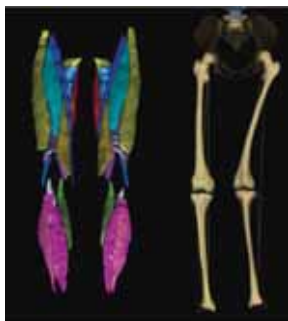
Example of a 3D subject-specific musculoskeletal reconstruction obtained from MRI and EOS® of an 11 year-old female patient with CP
